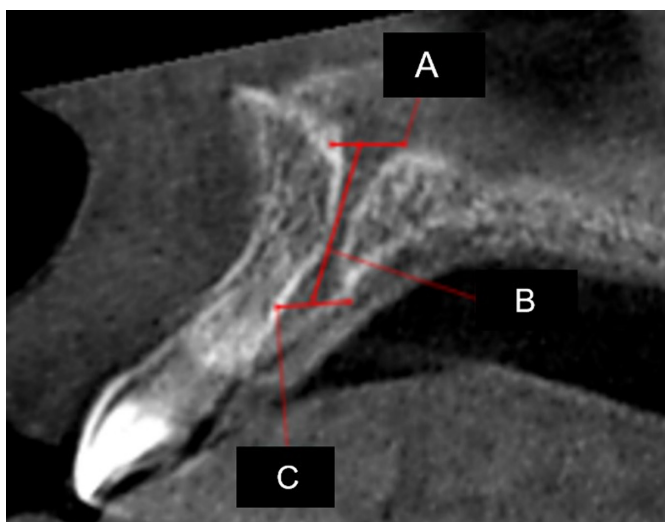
Anatomical structural measurements in sagittal sections on a cone-beam computed tomography image: Stensen's foramina diameter (A), nasopalatine canal length (B), and incisive foramen diameter (C).
